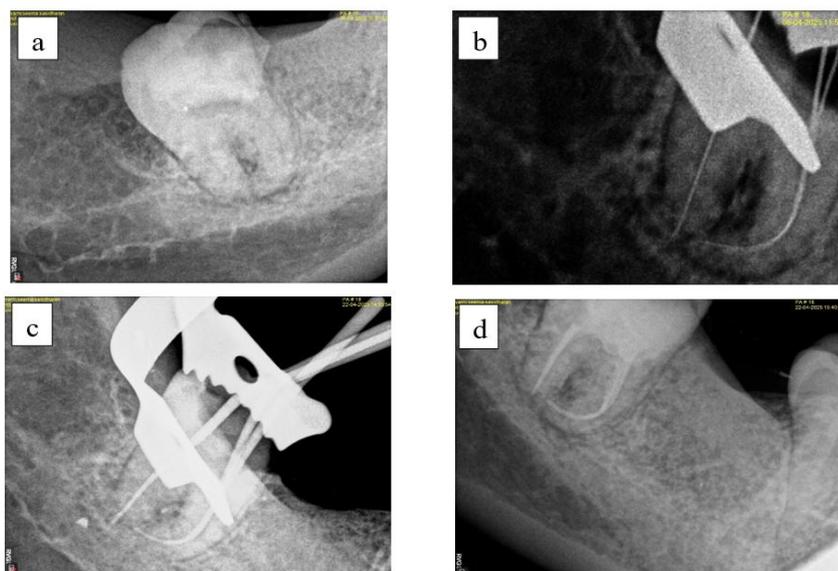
a) Pre-operative IOPA x-ray. b) working length IOPA x-ray c) Master apical cone IOPA x-ray d) Post-operative IOPA x-ray.
